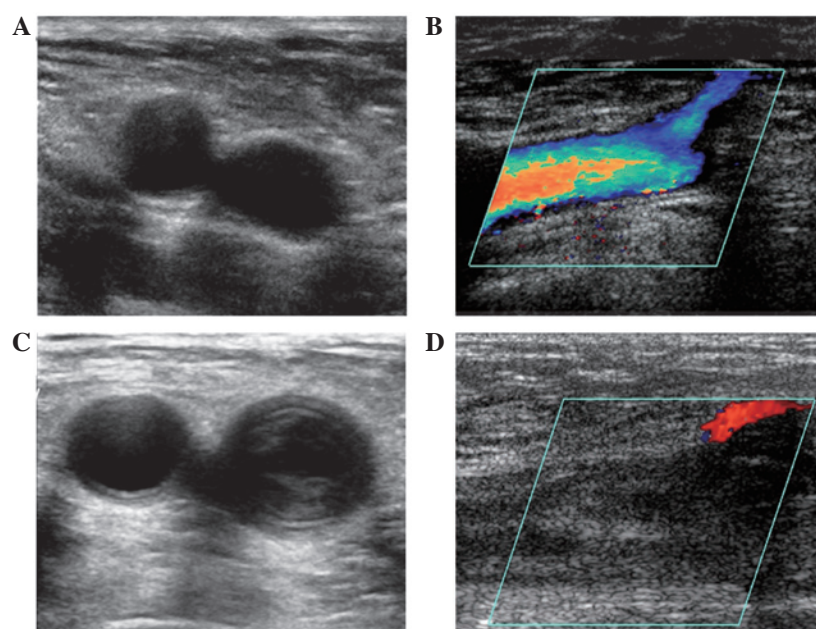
Color Doppler ultrasonography imaging of the deep vein thrombosis (DVT) and non-DVT groups. Color Doppler ultrasonography was performed to detect the size, localization, echogenicity, margins and tendency of the thrombus structure. In the non-DVT group, (A) coronal and (B) axial images revealed that non-significant stenosis occurred in the femoral veins. In the DVT group, (C) coronal and (D) axial images revealed that several thrombi and venous stenosis were present in the femoral veins.
